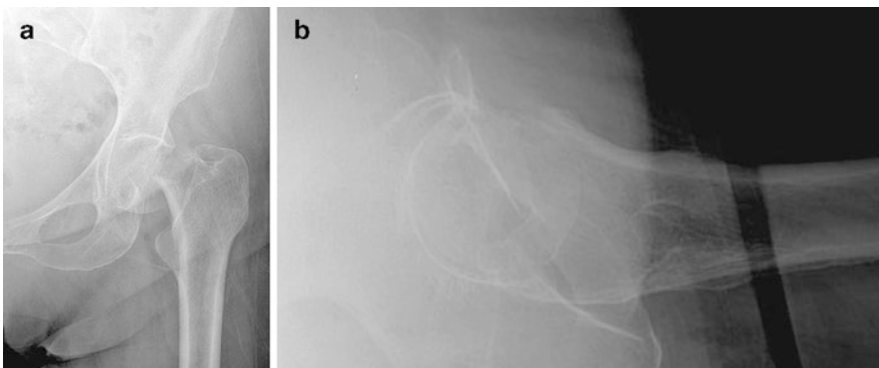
(a) AP radiograph of the hip. (b) Lateral radiograph of the hip
